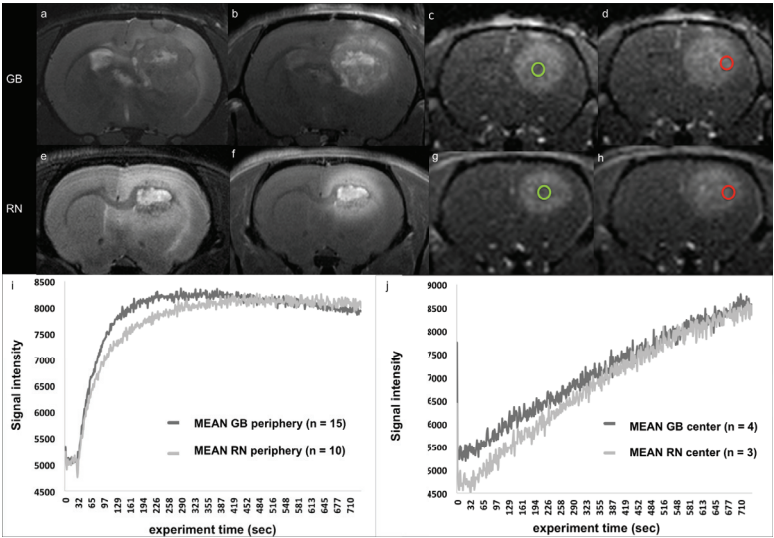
Both GB and RN are heterogeneously hyperintense on T2-weighted MR images (a, e). T1-weighted contrast enhanced MRI (b) shows a heterogeneously contrast enhancing tumor with relatively low-enhancing viable tumor cells at the outer rim of the lesion and high contrast enhancement in the center of the tumor corresponding to tumor necrosis. In late RN, a similar contrast enhancement pattern is observed (f). DCE-MRI images 6 min post-injection (c, g) show no visible contrast uptake in the center of the tumor or RN lesion. DCE-MRI images at the end of a 12-min acquisition (d, h) show equal high contrast uptake in all parts of the lesions. DCE-MR signal intensity within ROIs placed at the periphery of the lesion (red circle) and in the center of the lesion (green circle) was plotted as a function of time (raw data curves: i, j). In GB, the slope of the first exponential part is higher than in RN, reaching the maximal intensity faster than in RN.
